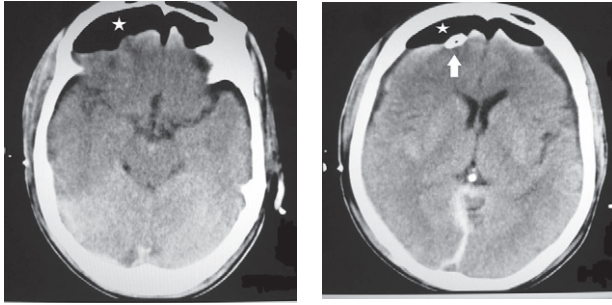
CT images showing the presence of bilateral frontal air collections (stars) displacing and compressing frontal lobes (Fig 1a, and 1b), and the presence of ICP monitor over right frontal lobe (arrow, Fig 1b). Note bilateral subdural collections and the interhemispheric blood.
